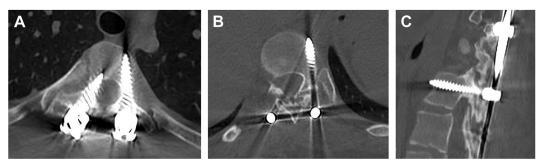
Axial computed tomography showing a thoracic pedicle screw breaching the medial cortical wall (A) and lateral wall (B), and sagittal computed tomography of a thoracic pedicle screw breaching the anterior vertebral wall (C).
